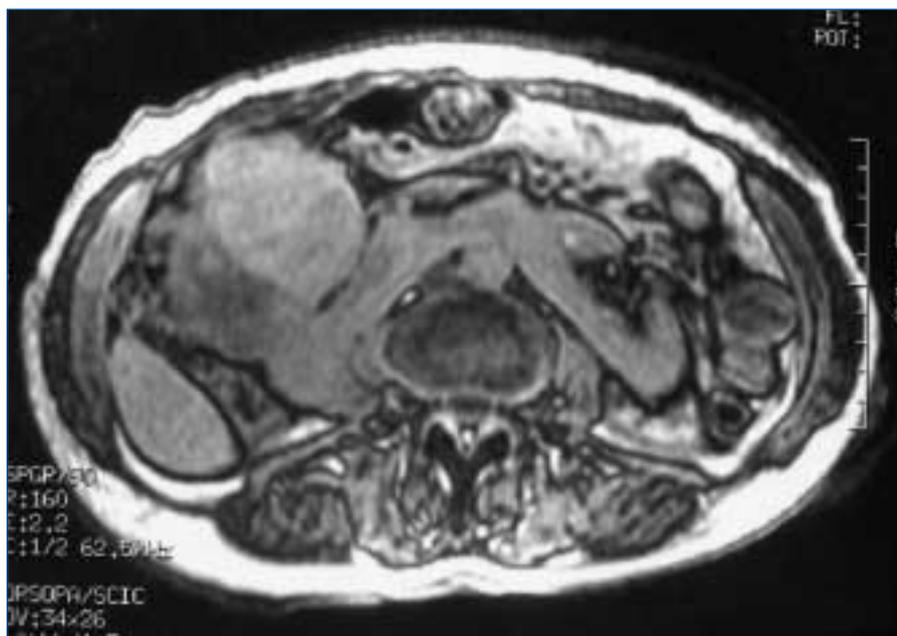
Magnetic resonance image, that shows a hypernephroma.
